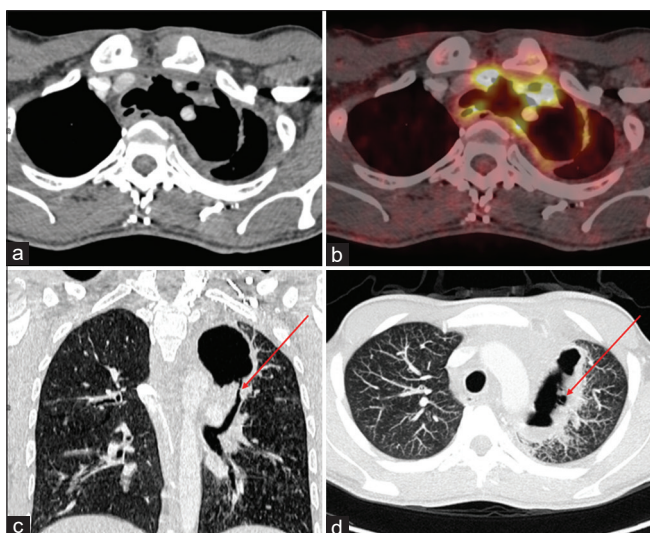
Computed Tomography Axial view (a) reveals a tracheoparenchymal fistula between the trachea and upper lobe of the left lung. A fused Positron emission tomography/computed tomography axial view (b) shows a metabolically active thick-walled tracheoparenchymal fistula in the upper lobe of the left lung communicating with the left lateral wall of the trachea. Computed tomography coronal and axial view in lung window (c, d) reveal direct communication of tracheoparenchymal fistula with the left upper lobar bronchus (red arrow)
